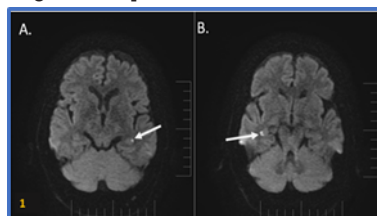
MRI showed punctate diffusion hyperintensities in bilateral Hippocampi (FIG 1A-B). Corresponding ADC maps showed low signal.
